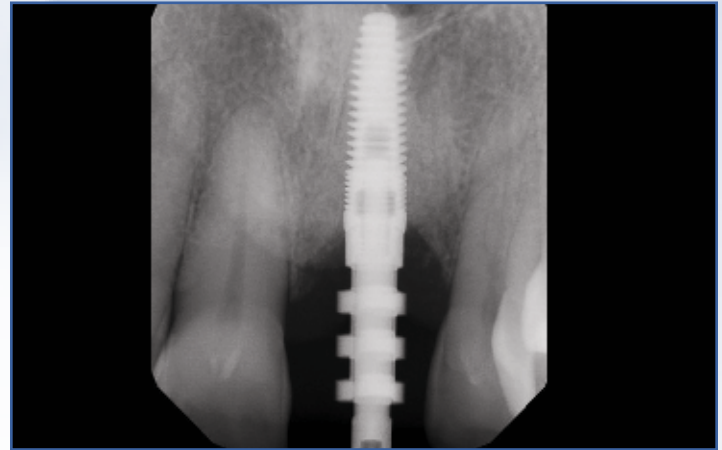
An open-tray technique was used to take a final impression of the implant site. After placing the impression coping, a radiograph was taken to ensure complete seating.
